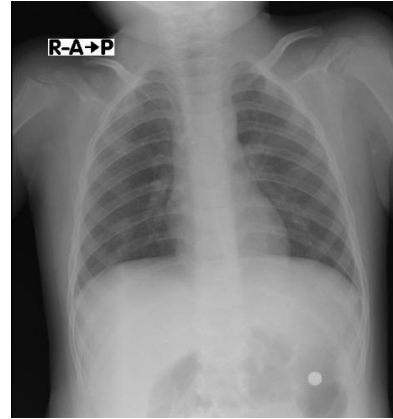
Chest X-ray (standing position) showed visible shadow of round opaque (foreign body), suspected in the stomach/intestine
